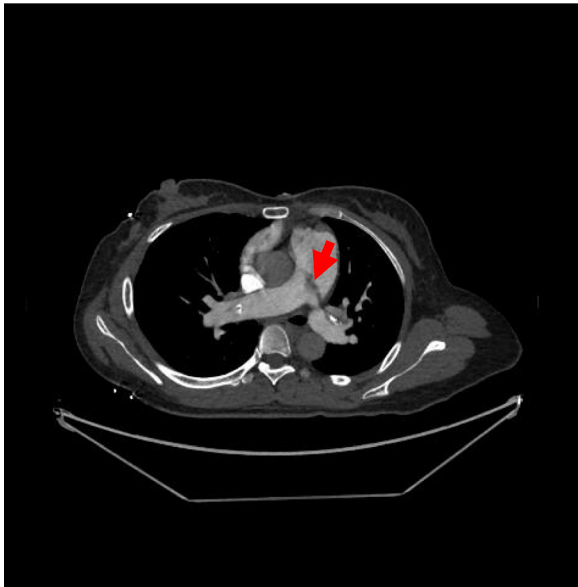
The computed tomography angiography (CTA). Axial image of the chest at the level of the bifurcation showing a filling defect
